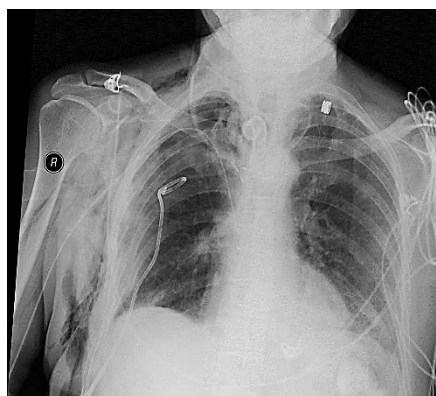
Mass Chest X-ray
